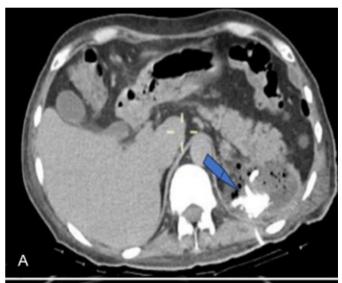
(A) A post-contrast CT scan of the abdomen, axial view, showing the fluid collection in the right posterior chest at the site of bullet entry and right calyceal injury. (B) CT scan abdomen, axial view, showing splenic injury and splenic abscess. (C) Bone window showing comminuted fracture of L1 vertebral body.
